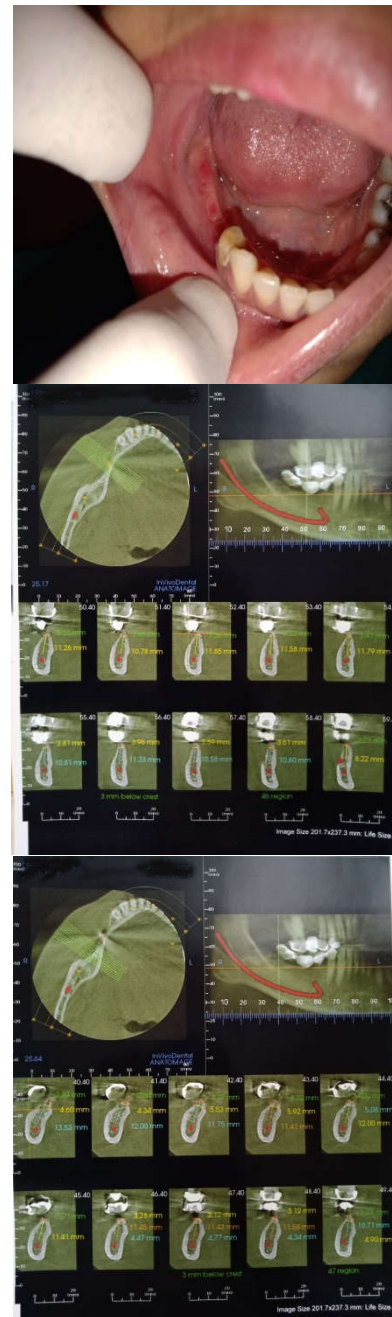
a: Clinical examination, 3b: CBCT of 46 region, 3c: CBCT of 47 region
